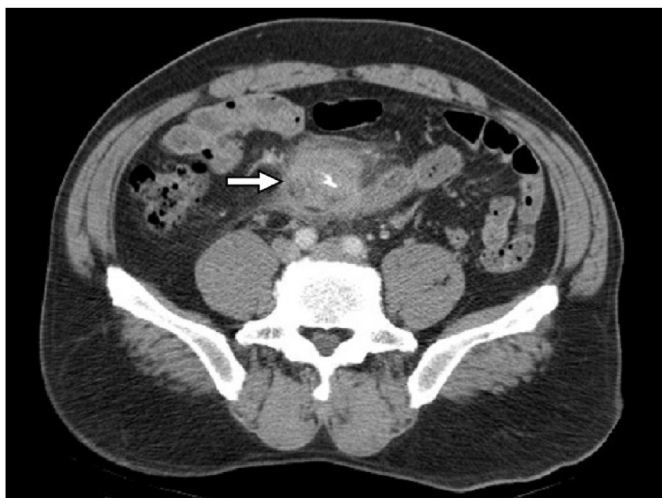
Axial view on contrast-enhanced computed tomography shows a spiculated mass with central calcification in the lower abdominal cavity (arrow), favoring a diagnosis of foreign-body retention.
